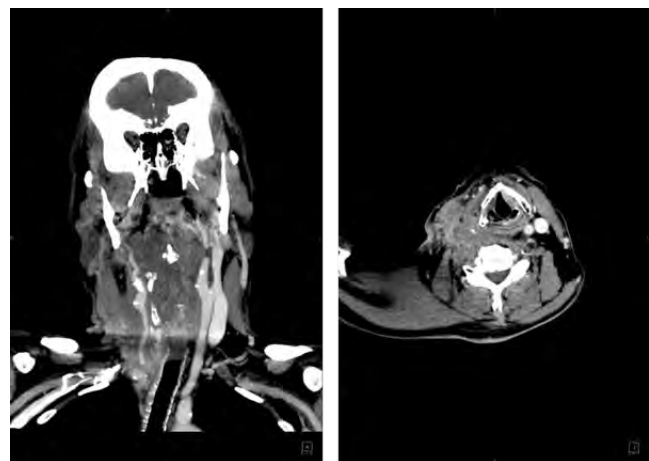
CT scan (coronal and axial) showing space-occupying mass in R carotid space (skull base to thoracic inlet)
